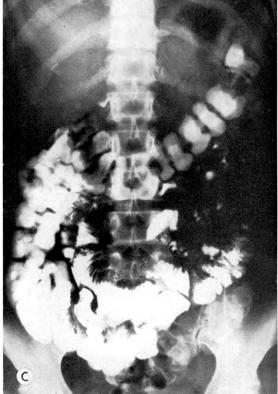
Case No. A3715. Studies of the small intestines with a mixture of barium sulfate suspension and a 25 per cent hypaque solution. Note the separation of the 2 contrast media as they proceed in the intestines. (A) Roentgenogram made 20 minutes after oral administration of the barium-hypaque mixture. The stomach, duodenum and proximal jejunum are well visualized. Note the beginning of slight separation of hypaque in mid small intestines. (B) Roentgenogram made after 1 hour. Barium is still in the jejunum while most of the hypaque is in the distal half of the small intestines and the proximal colon. (C) At 4 hours barium is in mid small intestines while hypaque outlines the distal ileum and the greater portion of the colon.
